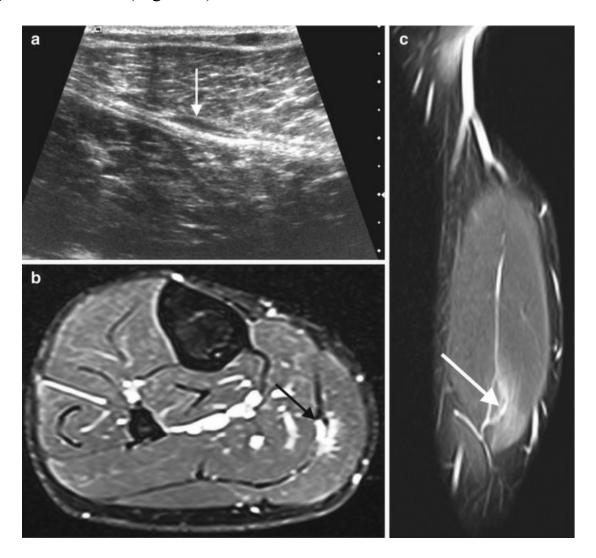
A 28-year-old athlete with acute medial calf pain. (a) Longitudinal ultrasound image shows a focal aponeurotic thickening of the medial gastrocnemius (*arrow*). Coronal (b) and axial (c) fat-suppressed T2-weighted MRI confirm grade 1 medial gastrocnemius aponeurotic injury (*arrow*)
